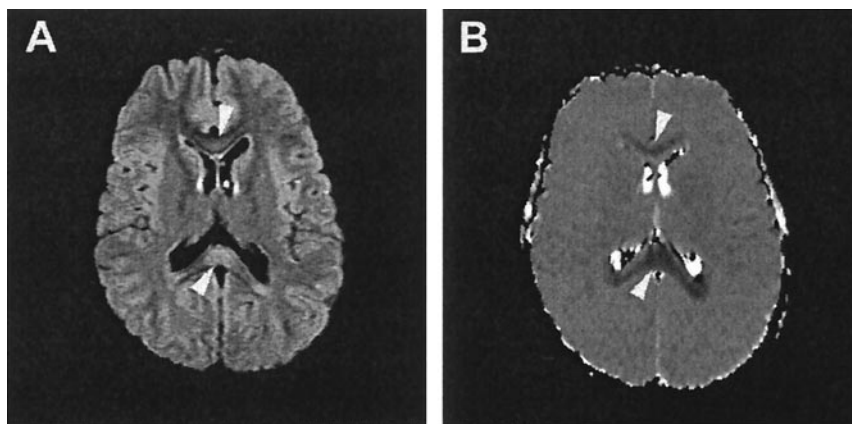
Axial MRI of the brain of patient 6. A, Axial fluid attenuated inversion recovery (FLAIR) image with arrowheads pointing to abnormal signal in the corpus callosum. B, Restricted diffusion on diffusion-weighted imaging shown by arrowheads.
